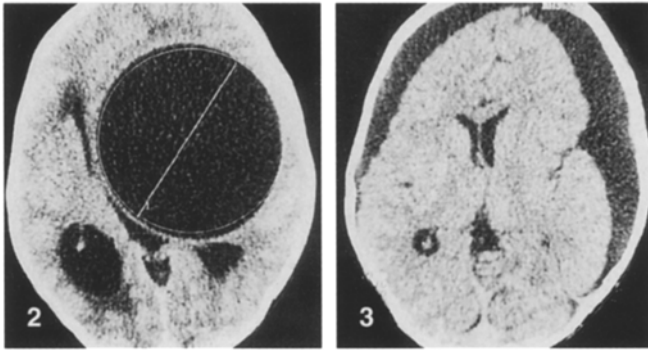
CT scan: unilocular left temporoparietooccipital giant CHCy
